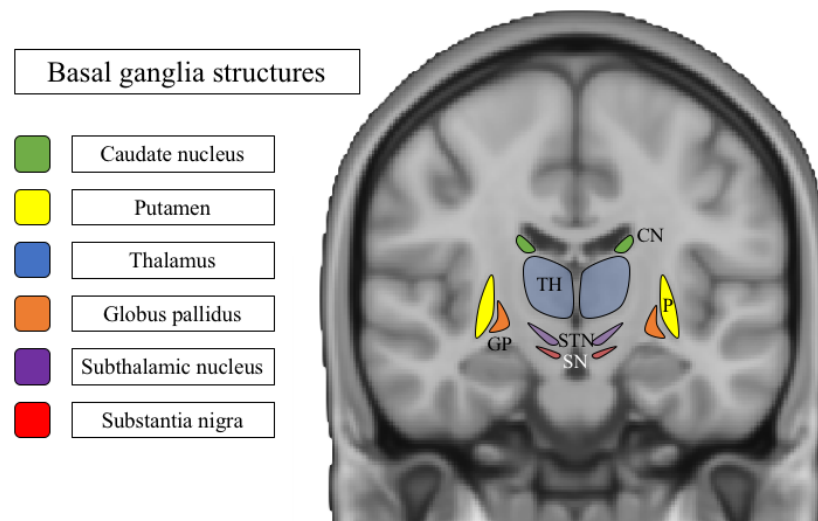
Structures of the basal ganglia. This figure displays the component structures of the basal ganglia overlaid on a Montreal Neurological Institute 152 standard T₁-weighted structural MRI scan in the coronal plane. Abbreviations: CN, caudate nucleus; TH, thalamus; P, putamen; SN, substantia nigra; STN, subthalamic nucleus; GP, globus pallidus.
